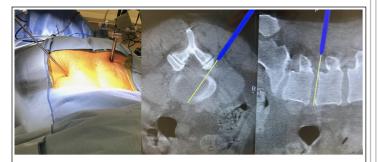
Placement of probe shown on body, as well as navigated projection from intraoperative CT scan.
